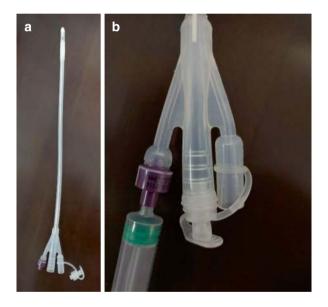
Triple-lumen urethral catheter. (a) A standard triple-lumen urethral catheter: the three lumens are, from left to right, the injection port for bladder flushing, the outlet port for urine, and the balloon port. (b) A modified triple-lumen urethral catheter for bladder flushing: the outlet port for urine is sealed with the piston of the balloon port to prevent rapid outflow of the injected fluid. The injection port is connected to a syringe filled with saline for bladder irrigation. The tip of the urethral catheter is placed at the site of the blood clot under ultrasound guidance to aspirate it
